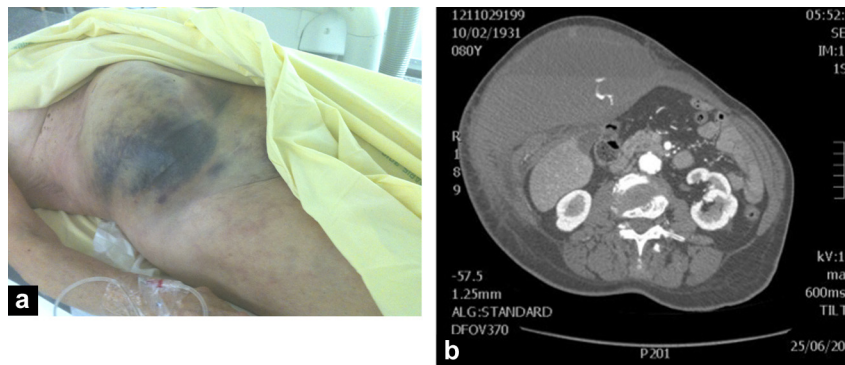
a and b: 72-year-old patient presenting with a voluminous hematoma of the right anterolateral abdominal wall, that occurred 3 days after starting anticoagulation at preventive doses with low molecular weight heparin following surgery for total knee prosthesis. (a) shows an extensive hematoma. Computed tomography (CT) angiography (b) confirms the presence of a hematoma in the anterior abdominal wall (rectus, external oblique, internal oblique and right transverse). CT angiography shows extravasation of contrast material through the inferior epigastric artery, clearly visible on (a) and (b). The patient will undergo selective embolization of the inferior epigastric artery.
